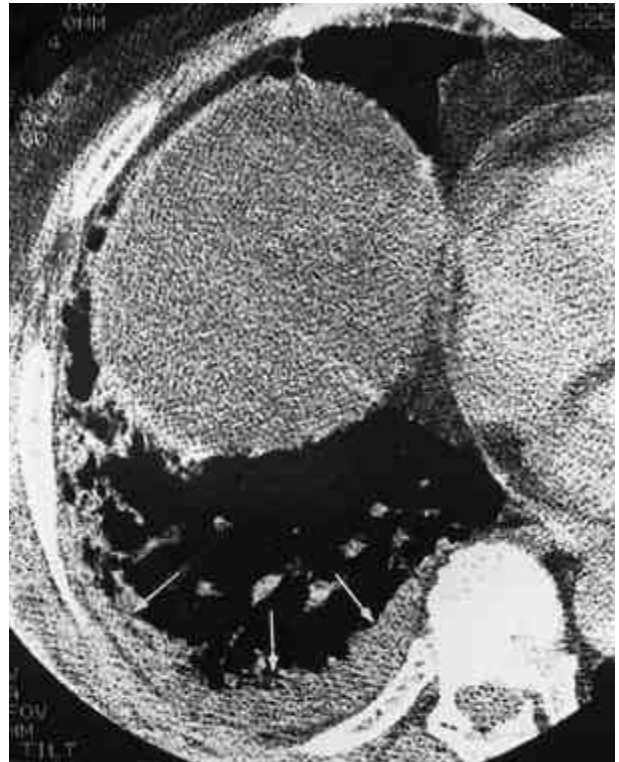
High-resolution CT of a 62-year-old woman with polymyositis shows right pleural effusion (arrows).
